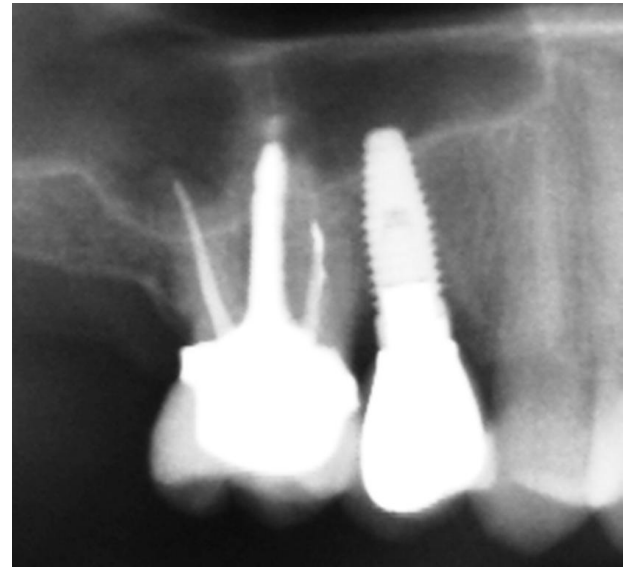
Radiograph showing restored implant at site # 15. Apical portion of the implant is seen penetrating the sinus floor. (1 year post-operative)
